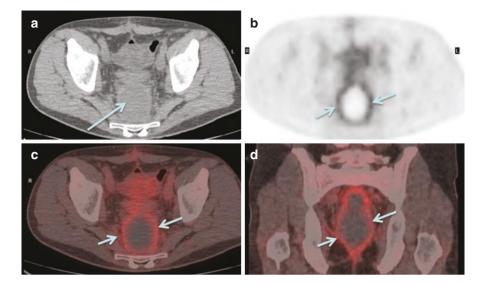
Role of FDG PET-CT in recurrent colorectal cancer. 50-year-old with man with suspected recurrence following abdominoperineal resection for rectal cancer. FDG PET-CT performed 8 weeks post-surgery. Axial CT (a) demonstrates a presacral abnormality with central low density (long arrow). Axial PET image (b) and fused PET-CT images in the axial (c) and coronal planes (d) demonstrate symmetrical diffuse peripheral low grade uptake in the walls of the cavity (short arrows). Note the absence of any nodular areas of asymmetrical high intensity uptake and the usefulness of the coronal plane to demonstrate the entire extent. Above appearances are typical for a post-surgical inflammatory collection/abscess with no evidence to suggest local recurrence
